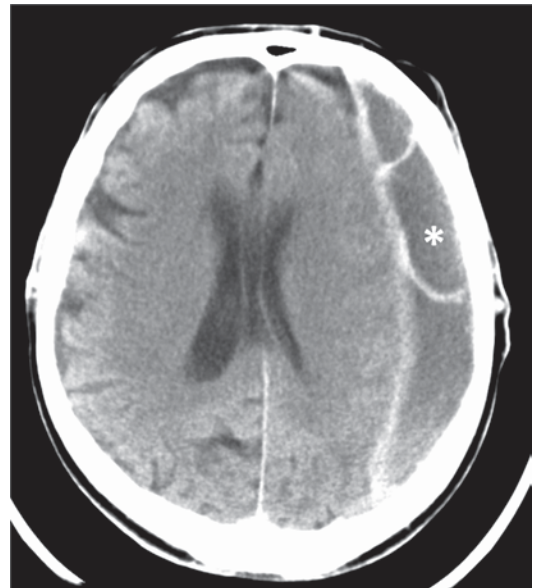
CT scan of chronic subdural hematoma with mixed densities, hyperdense, and isodense (*asterisk*). (Courtesy of Dr. Blaine Hart)
